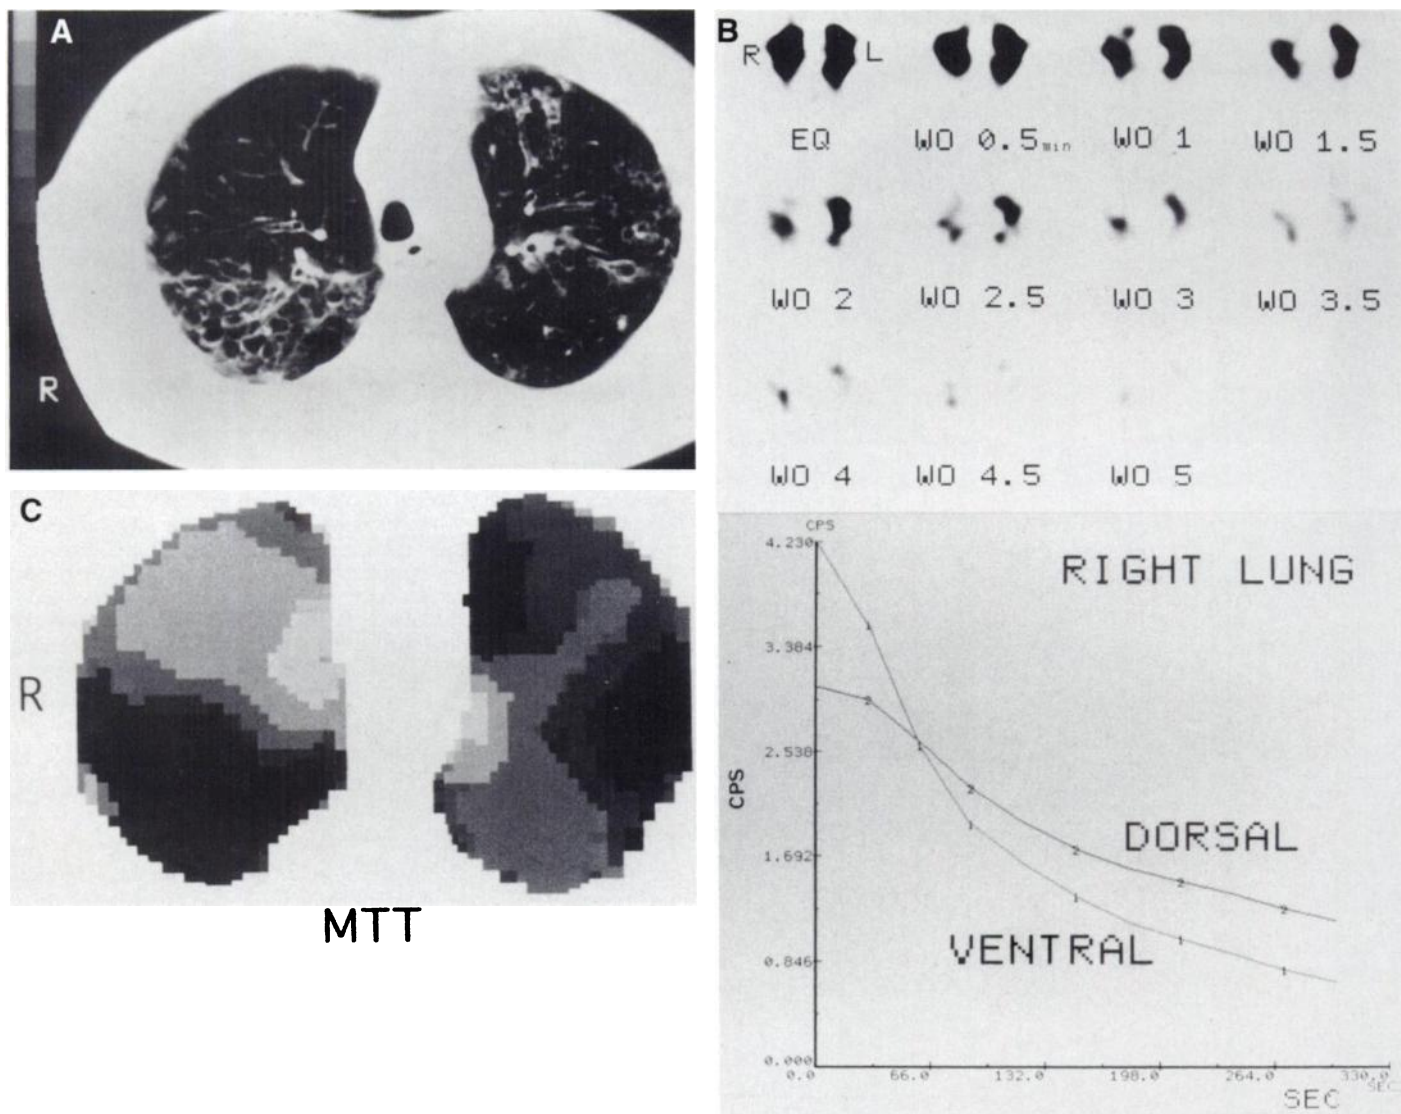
(A) Chest CT scan from a 63-yr-old woman with chronic bronchitis shows bronchiectasis in both upper lobes, while the change is slight in the right ventral portion. (B) SPECT shows heterogeneous washout in both lungs (top). Washout curves in right lung show more reduced initial ^{133}Xe activity and more prolonged $T_{1/2}$ (222.9 sec) in dorsal portion with severe bronchiectasis than the ventral portion (81.7 sec) (bottom). (C) MTT image shows heterogeneously prolonged MTT, which is more prolonged in the right dorsal than ventral portion.
